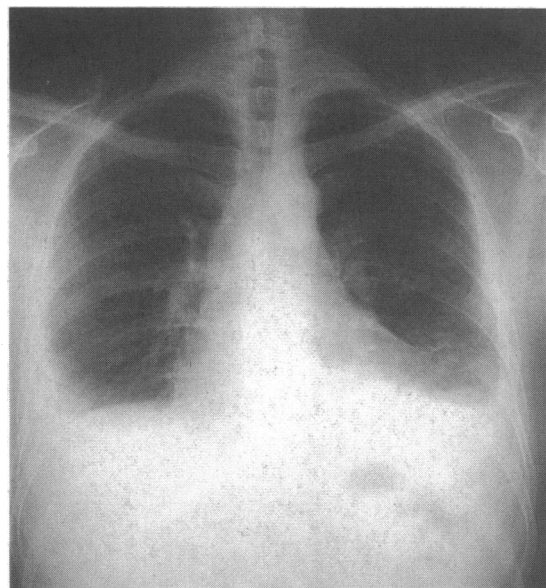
Chest radiograph on admission to hospital. Cardiomegaly, small pleural effusions, and septal lines in both lower zones are visible
